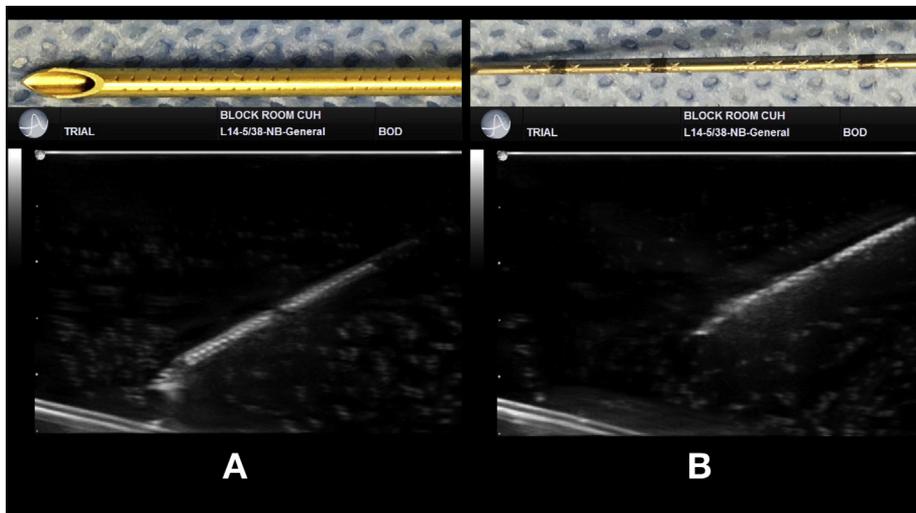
(A) Image of Pajunk SonoLong NanoLine 19G ultrasound optimised needle (Pajunk, Geisingen, Germany) above an ultrasound image obtained in a water bath. Note the embossed 'Cornerstone[®]' pattern on the needle and the resultant ultrasonographic enhancement of needle shaft. (B) Image of B. Braun's Stimuplex Ultra 360 A50 (B. Braun Melsungen, Melsungen, Germany) above an ultrasound image obtained in a water bath. Note the X-shaped grooves on the needle shaft and the resultant ultrasonographic enhancement of the needle shaft.
